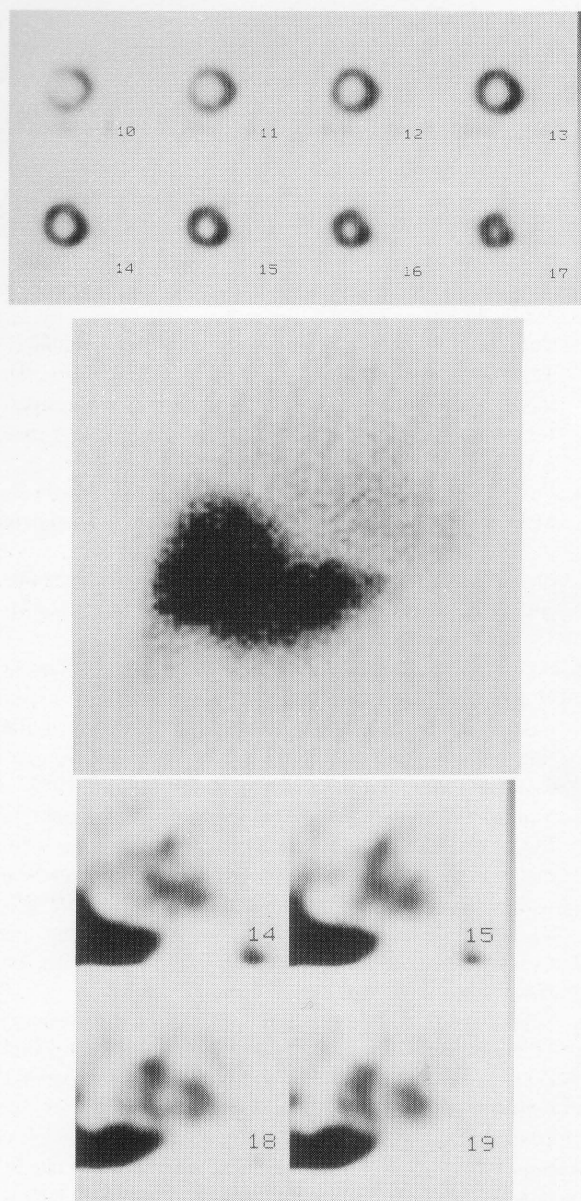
Planar and SPECT images in a 66-year-old sister of 72 year-old-woman, Upper panel: resting ^{201}Tl SPECT reveals essentially normal myocardial perfusion. Middle and Lower panel: BMIPP chest anterior planar (middle) and SPECT (lower) images show no myocardial uptake and only blood pool activity can be seen.
